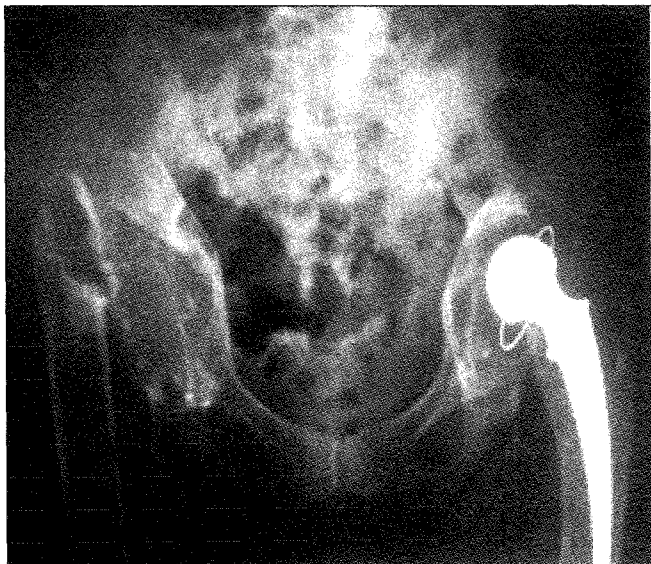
Antero-posterior radiograph of the pelvis showing right Girdlestone arthroplasty and left Charnley THA with acetabular component loosening and low bone stock acetabulum
